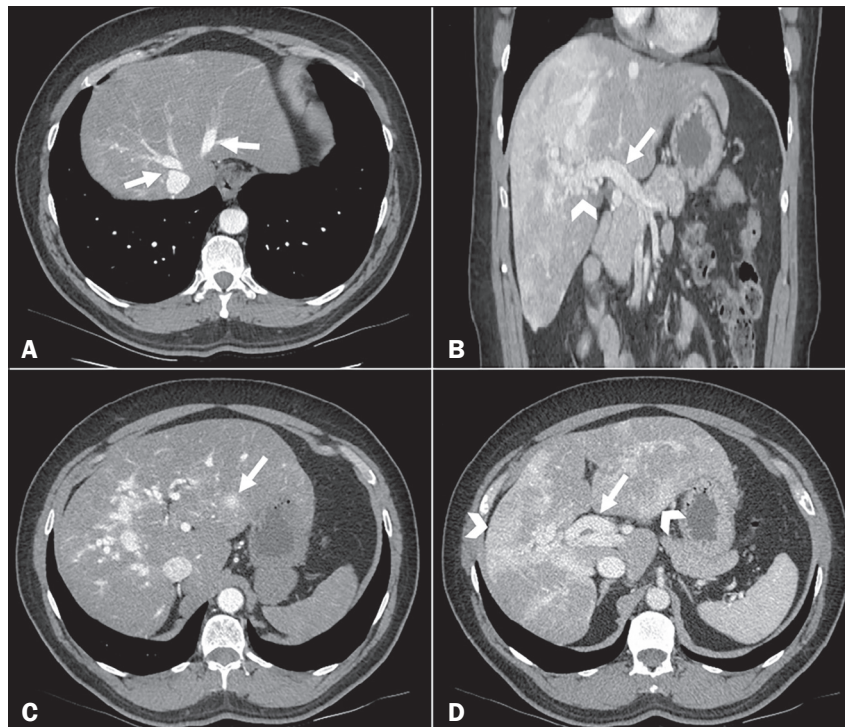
Computed tomography scan of the abdomen in axial slices (A, C, and D) and in a coronal slice (B). A: Note the opacification of the hepatic veins in the early arterial phase (arrows). B: Heterogeneous opacification of the portal vein during the portal phase (arrow), accompanied by numerous ectatic vascular structures surrounding the hepatic hilum, representing an arteriovenous malformation (arrowhead). C: Confluent vascular mass, measuring 1.4 cm, in segment II (arrow). D: Extensive areas of altered perfusion in the hepatic parenchyma, in a mosaic pattern (arrow heads), together with increased caliber of the hepatic artery (arrow).
